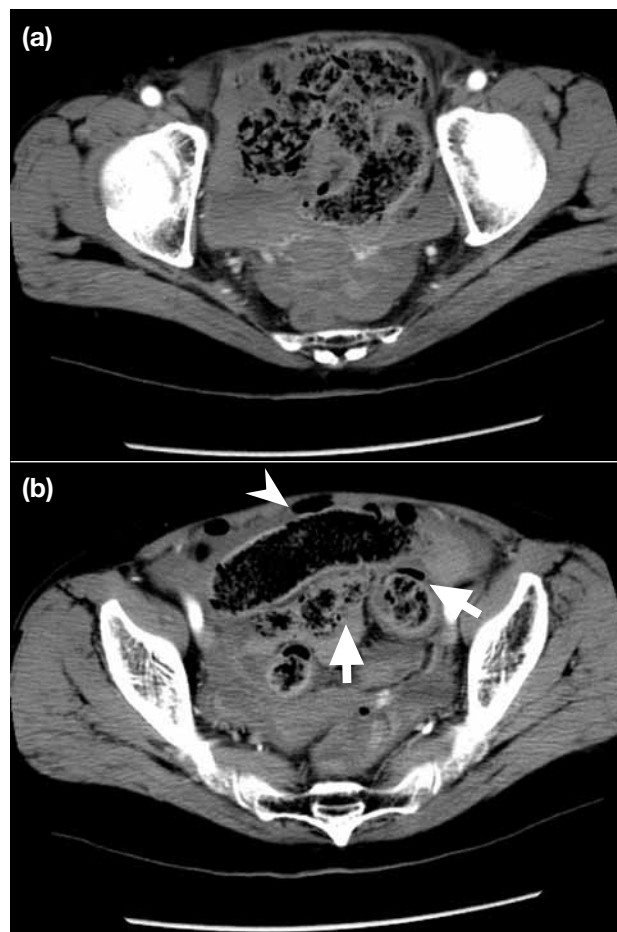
Axial contrast computed tomography of the pelvis shows pneumoperitoneum, pneumatosis coli and free-lying faeces in the pelvis. Axial scans show (a) free-lying faeces and (b) pneumoperitoneum (arrowhead) and pneumatosis coli (arrows)
